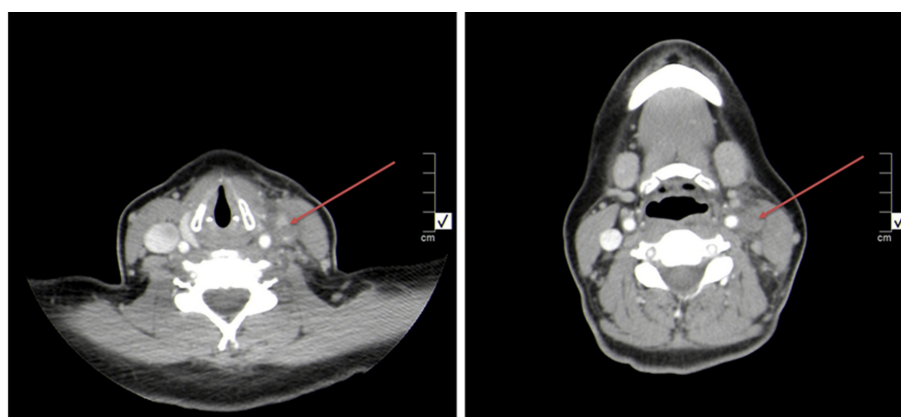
The cervical computed tomography scan with intravenous contrast of a 41-year-old female patient showing thrombosis (arrows) at the cervical portion of the left internal jugular vein.
